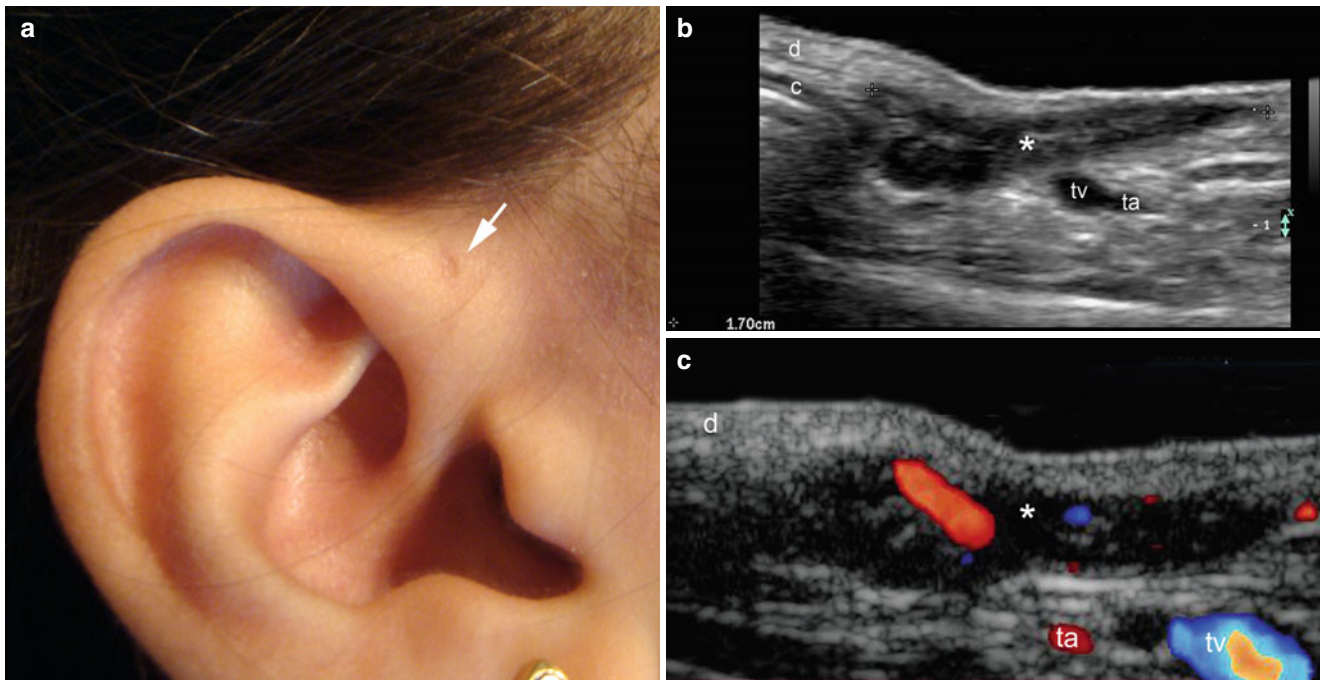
(a–c) Preauricular sinus. (a) Clinical image shows a small dimple in the right pre-auricular region (*arrow*). (b) Ultrasound image (gray scale, transverse view) demonstrates 1.7 cm long hypoechoic sinus tract (*) located superficial to the temporal vessels and closely
